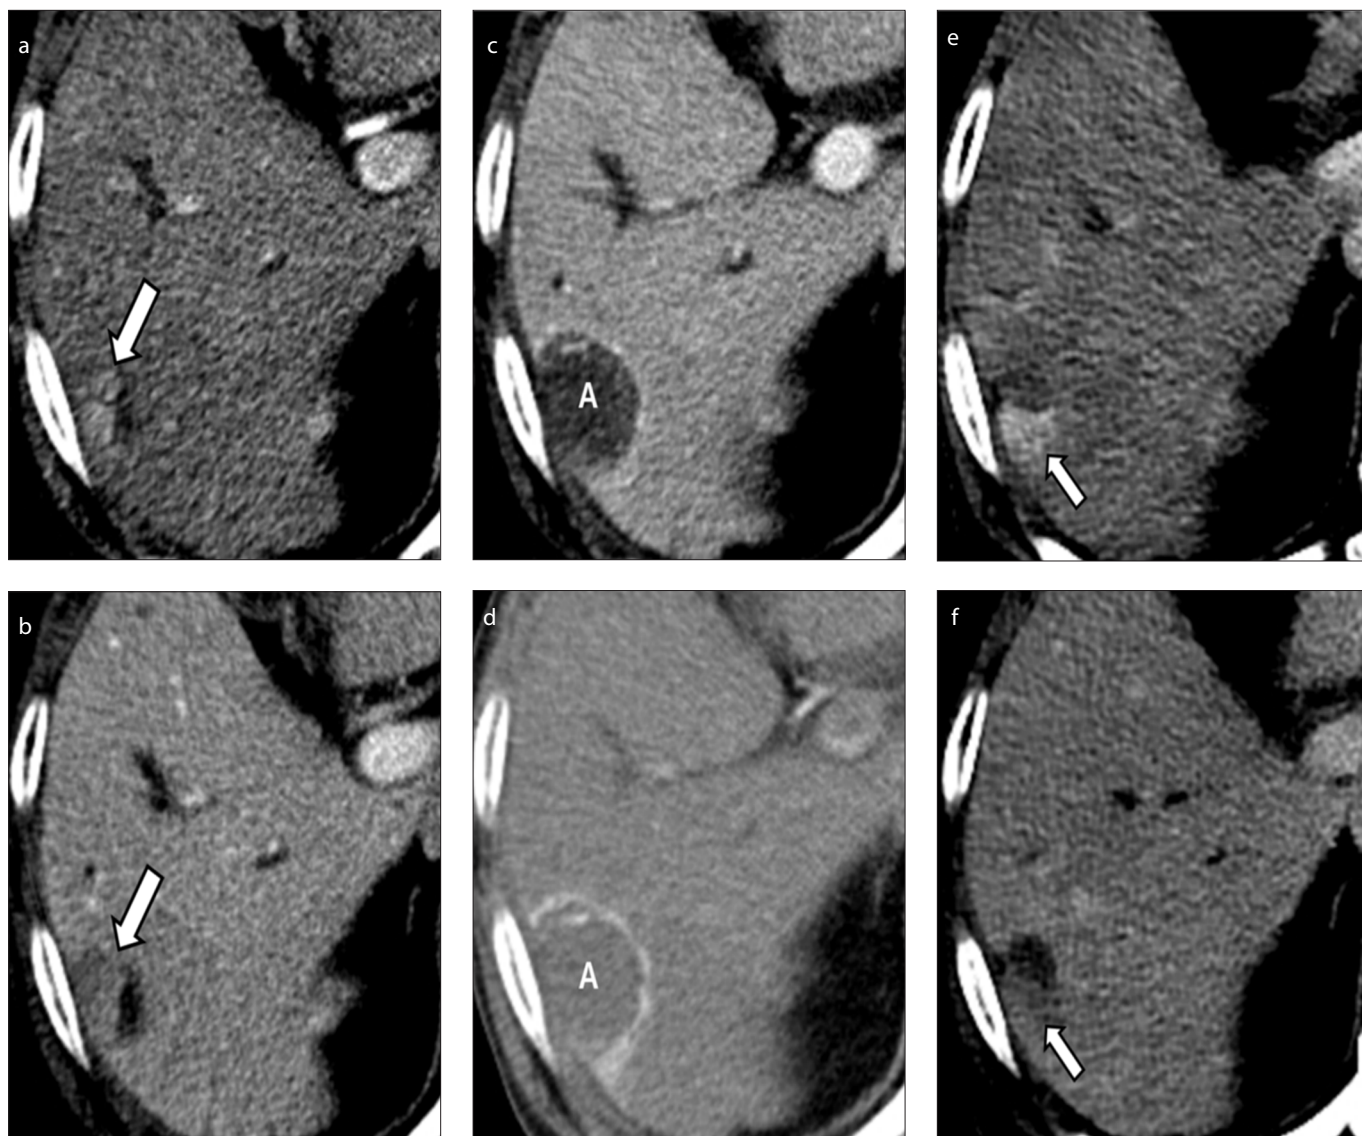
a–f. A 75-year-old man with hepatocellular carcinoma (HCC) treated with percutaneous cryoablation (PC). Liver dynamic computed tomography (CT) images (a, b) demonstrated an enhancing mass with washout on portal phase in segment 6 measuring 2 cm (arrow), suggesting HCC. Follow-up CT images (c, d) obtained at 1 month after PC. The tumor was completely replaced by ablation zone (a), but its MAM was 3 mm, measured on axial plane. Follow-up CT images (e, f) obtained at 1 year after PC showed local tumor recurrence.
